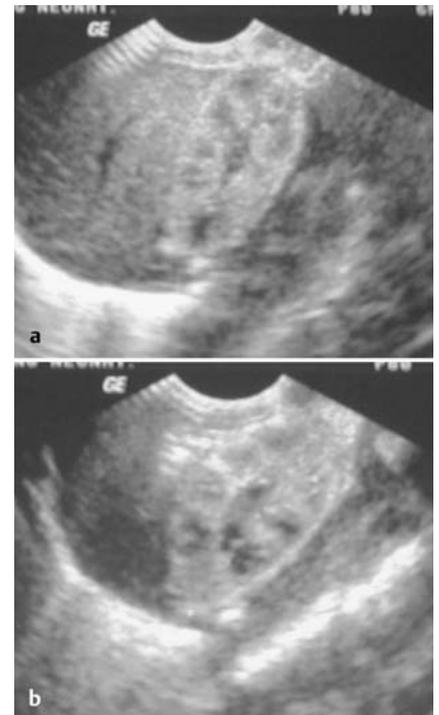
a and b Ultrasound after *Opium* C200 showing normal kidneys (a right, b left).
